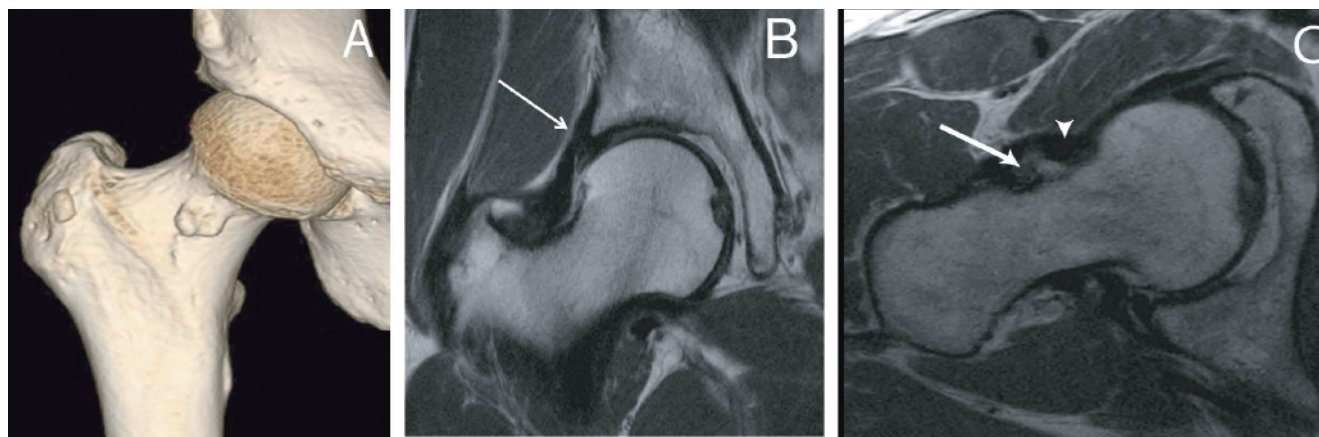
(A) 3D CT reconstruction of the right hip demonstrating the osteochondroma on the medial aspect of the femoral neck. (B) Coronal MRI of the hip demonstrates an anterosuperior labral tear that is nondisplaced (arrow). (C) Swiss axial MRI of the hip demonstrates the osteochondroma (arrow) with thickening of the anterior capsule (arrowhead) adjacent to the lesion.
